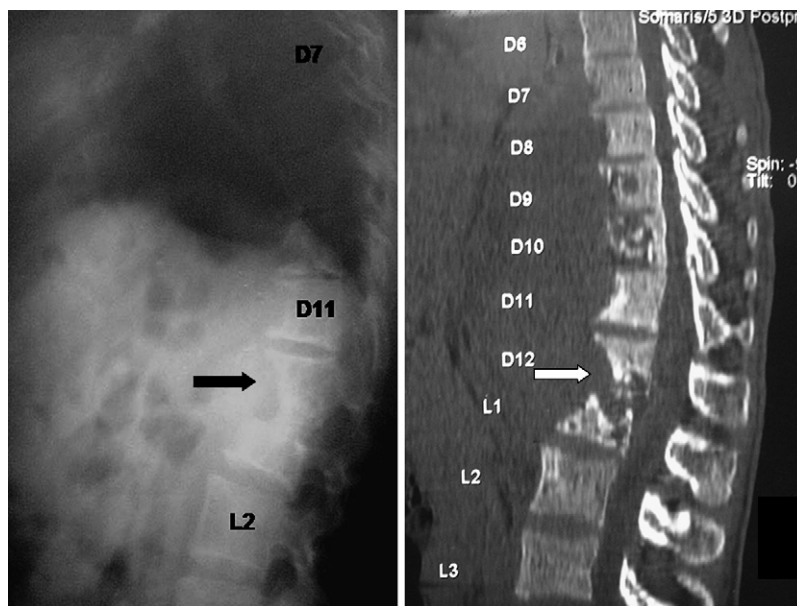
X-ray lateral view and sagittal computed tomographic scan showing bone destruction along with scalloping of anterior vertebral bodies in dorsolumbar region (D7–L2).
